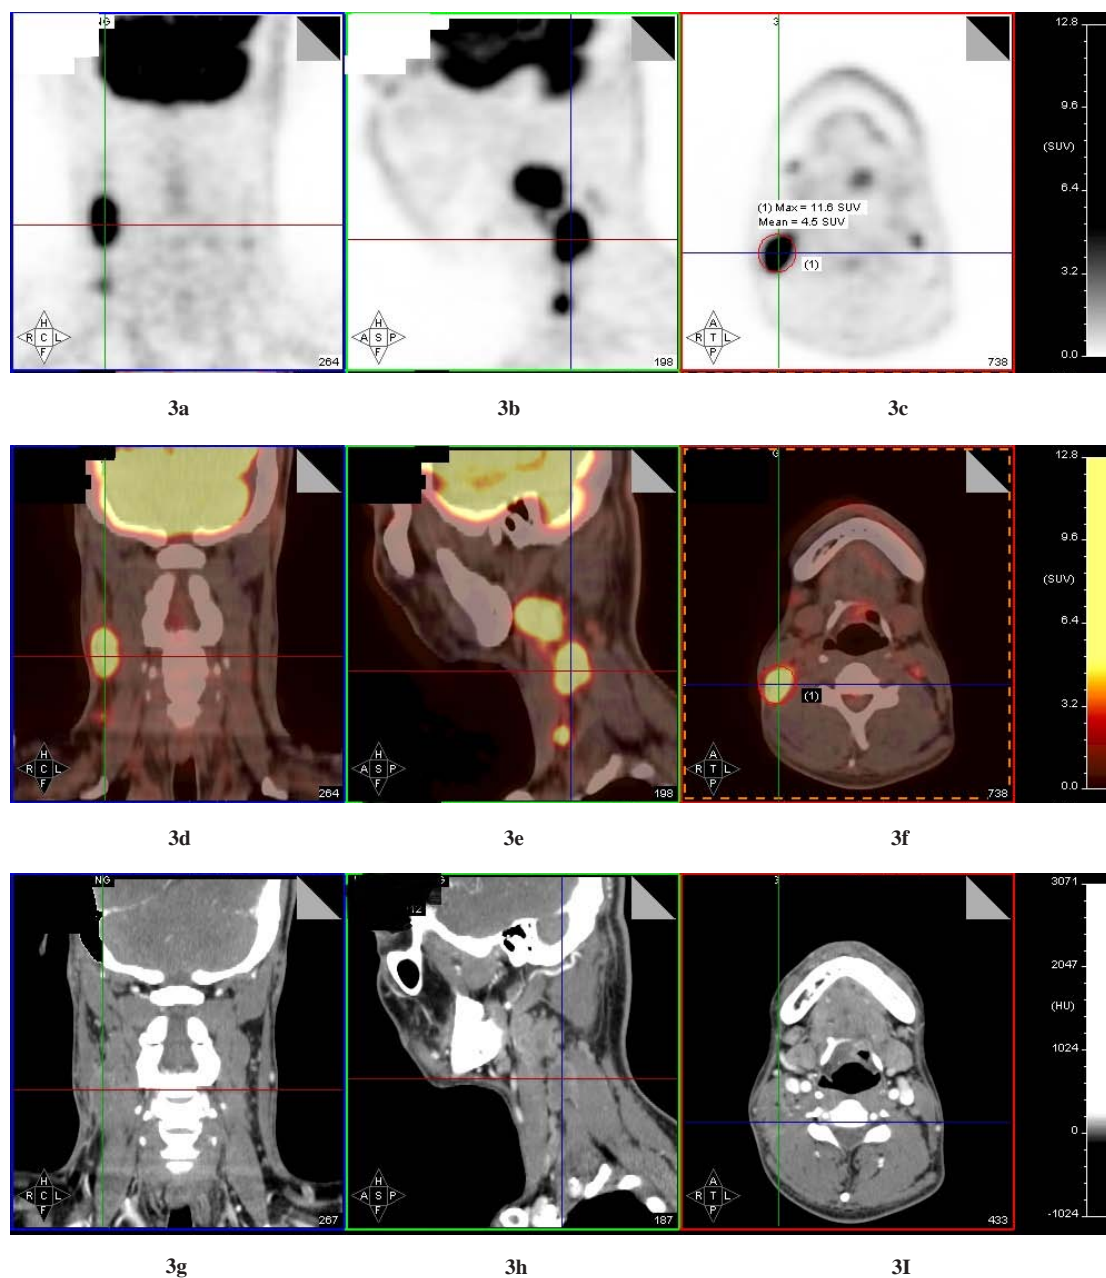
fig.3c were the coronal, sagittal and axial PET scanning images of lymph node of left-cervical V zone, showing FDG uptake increase,  $SUV_{max}$ : 4.2. Fig.3g-fig.3i were the coronal, sagittal and axial enhanced CT scanning images of this lymph node, which also showed the FDG uptake increase and lymph node enhancement of cervical lymph node. Fig.3d- fig.3f were respectively the fusion of fig.3a-fig.3c and fig.3g-fig.3i, showing the enhancement and FDG uptake increase of this lymph node.
